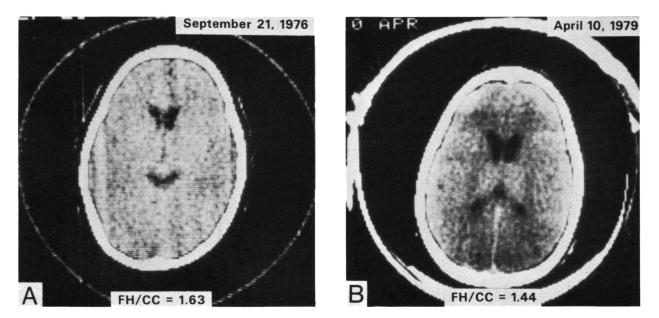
A) — The initial CT scan shows mild ventricular enlargement which was suggestive of cerebral atrophy. The bifrontal (FH) to bicaudate (CC) ratio was 1.63. B) — A repeat CT at age 4 years shows findings compatible with Huntington's disease. Note the "squaring off" of the frontal horns and the FH/CC of 1.44 (see text).
